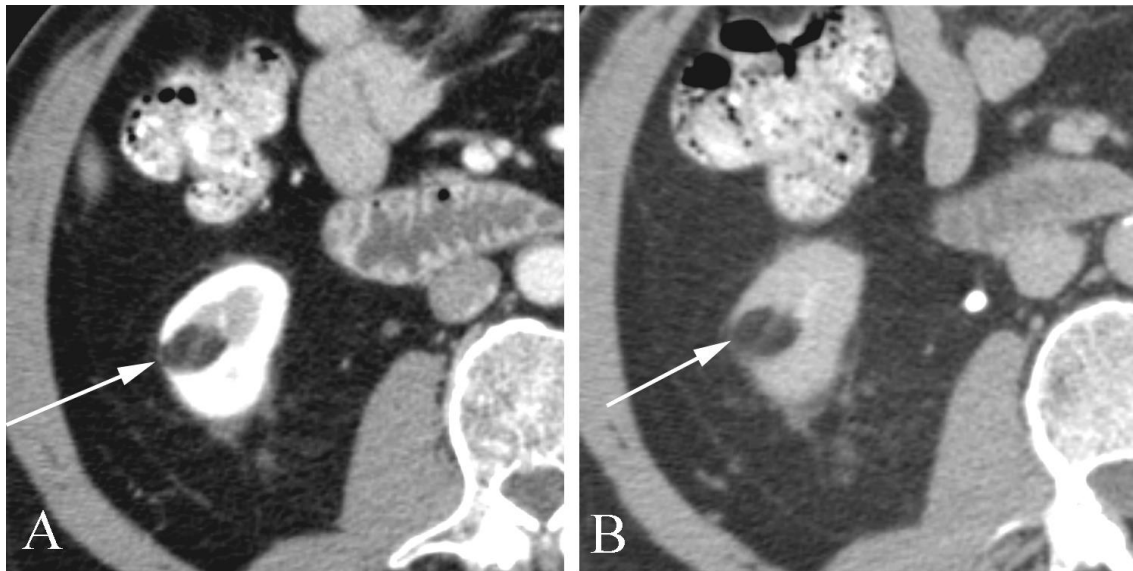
Renal angiomyolipoma in a 73 year old man with unrelated abdominal pain. A. Early, nephrographic phase CT shows a circumscribed, fat density mass of the right kidney (arrow), demonstrating the same density as the perinephric fat. B. Delayed examination shows the same lesion (arrow), which again demonstrates fat density. This lesion was unchanged five years later.
